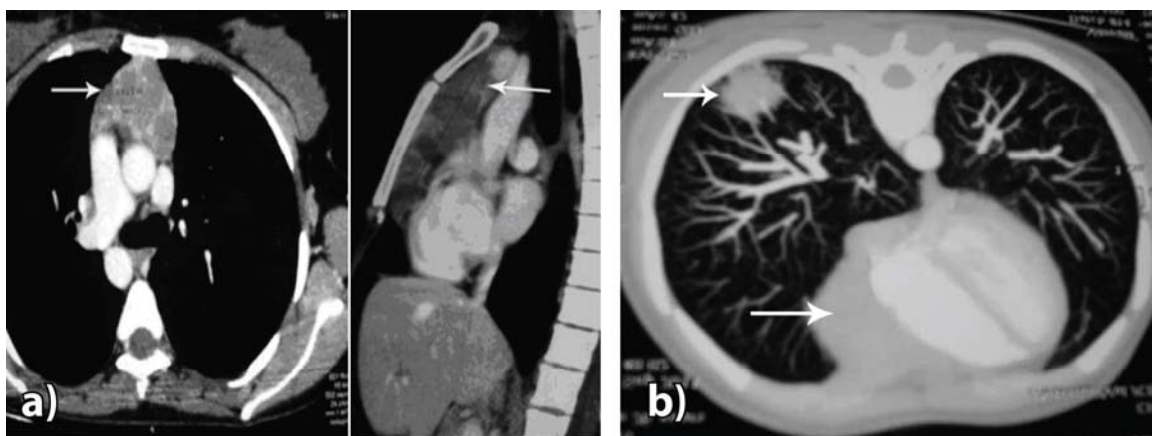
The multislice computed tomography (MSCT) of the thorax: a) A change in the upper anterior mediastinum (arrows); b) Oval change on the right lung and change in the upper anterior mediastinum (arrows).
